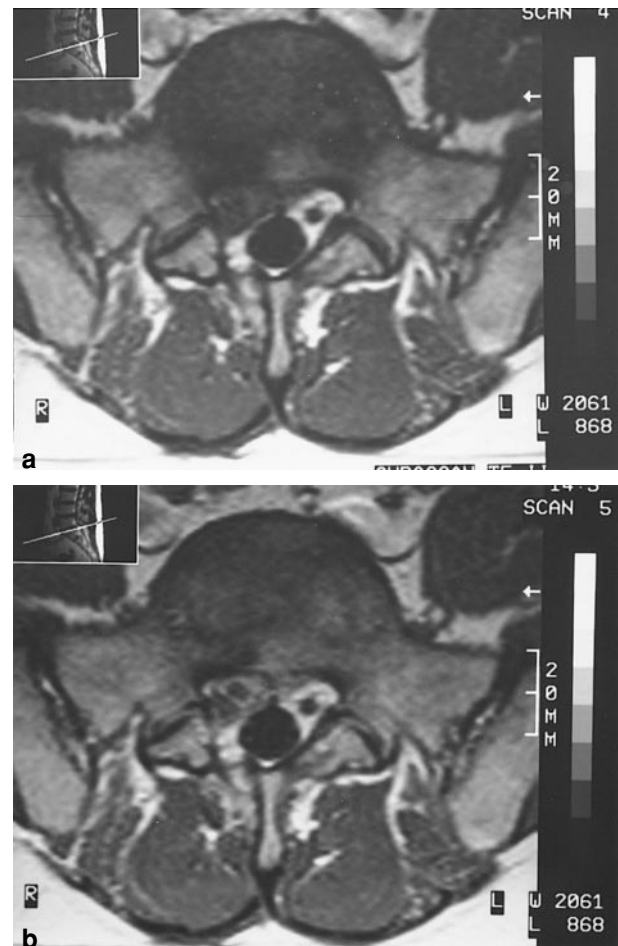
(a) Nonenhanced T1-weighted axial MRI at L5-S1 level shows a mass anteriorly and to the right in the spinal canal. The left S1 root is clearly seen (surrounded by bright fat tissue). The right S1 root can not be identified. (b) Post contrast scan reveals an anteriorly displaced nerve root surrounded by moderately inhomogenous enhancing tissue consistent with scar formation. Enhancement in the periphery of the nerve root is clearly seen
